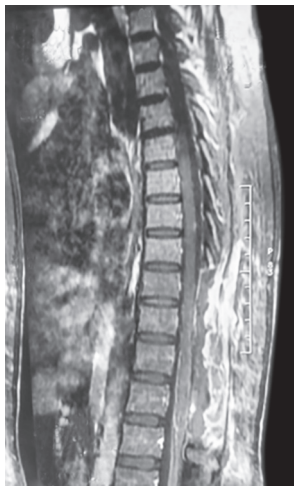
Postoperative T1 + contrast MRI sagittal image
